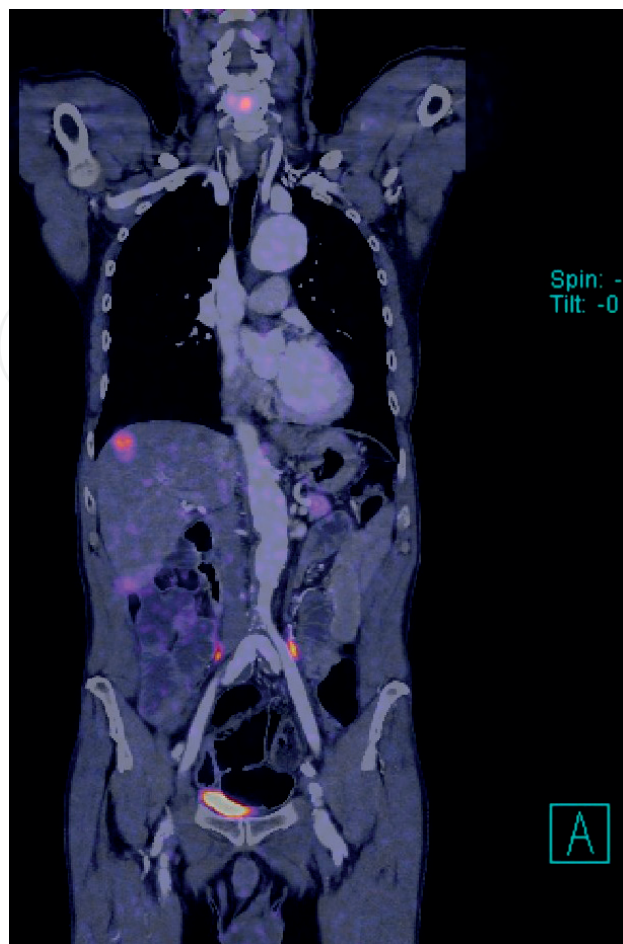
AAA and liver metastasis (PET MRI).
